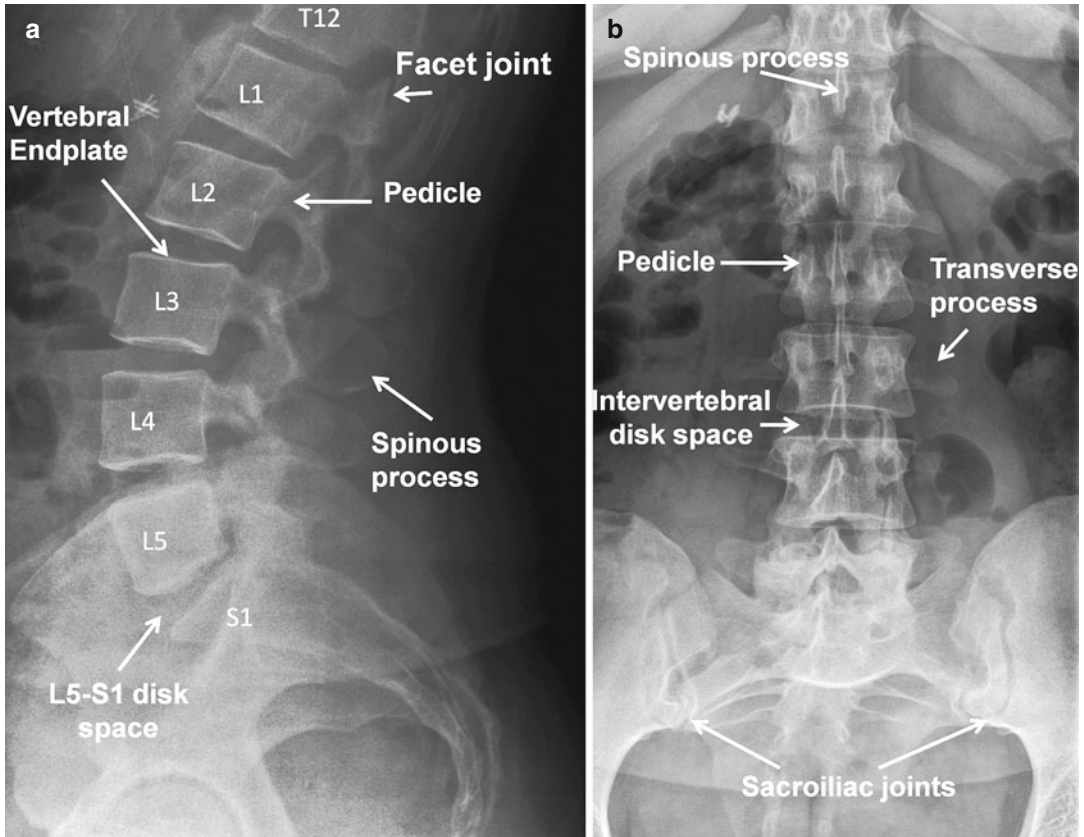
Lateral (a) and frontal (b) radiographs of the lumbar spine with pertinent radiographic anatomy labeled
